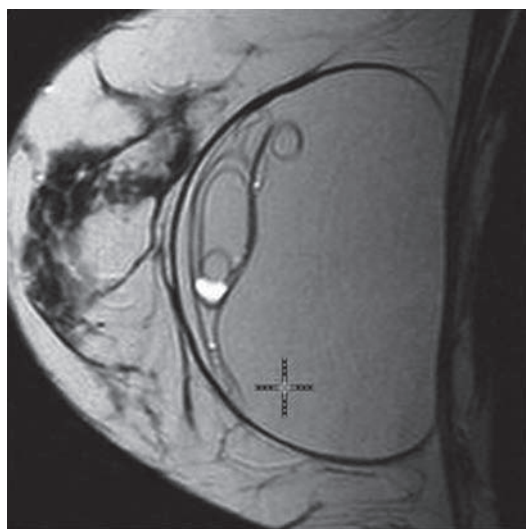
Example of subglandular implant with intracapsular and extracapsular rupture as seen on MRI.
